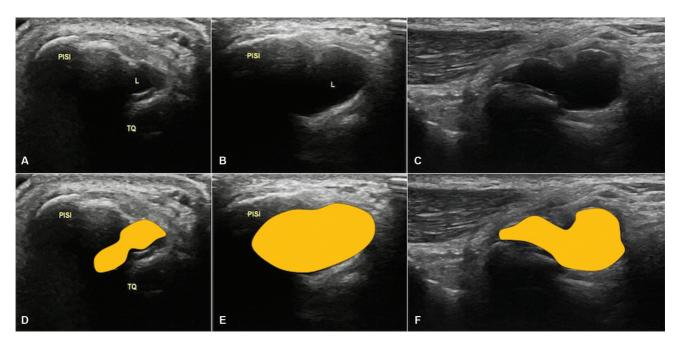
Ultrasound short-axis (A–E) and longitudinal (C, F) images show a well-defined hypoechoic lesion arising from the pisotriquetral joint space (yellow). L, lesion, PISI, pisiform.
